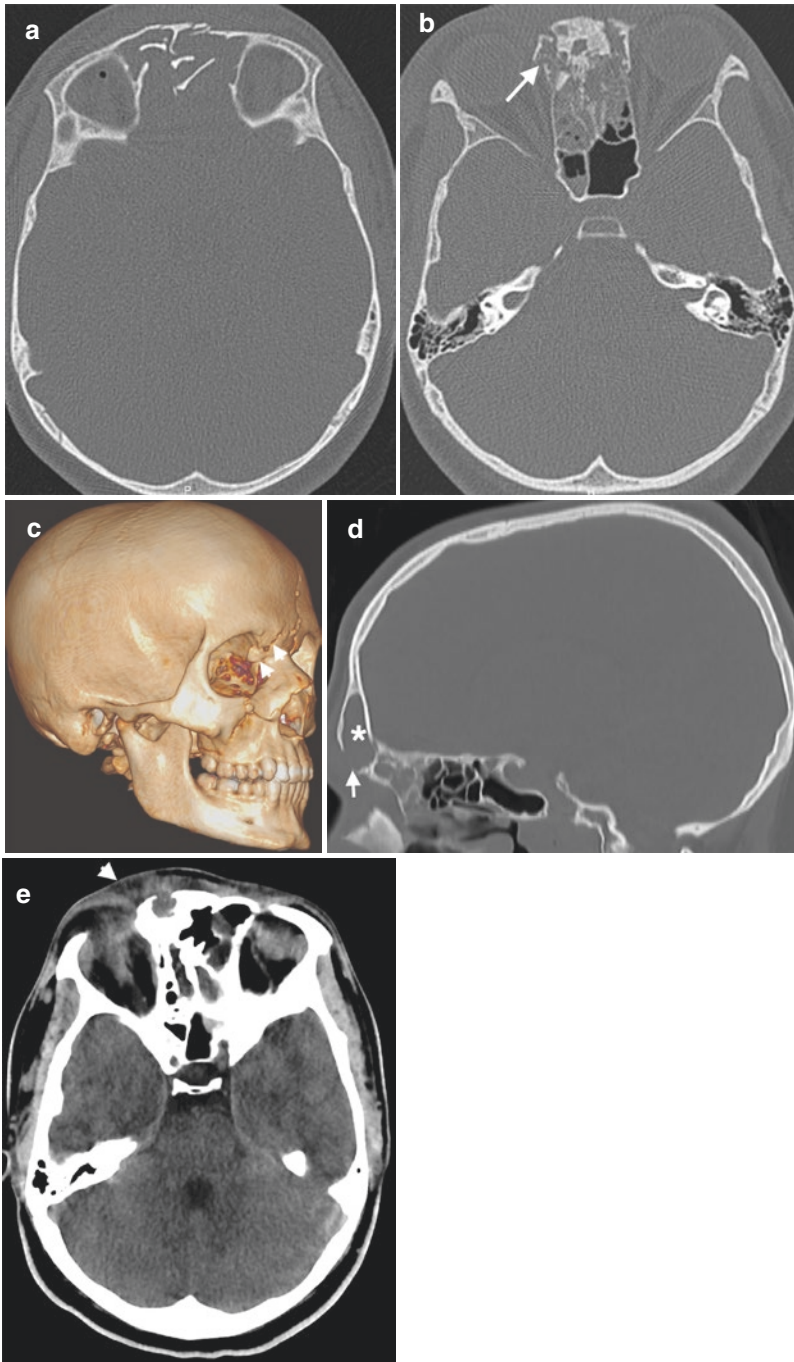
Mucopyocele formation secondary to nasofrontal duct injury. (a) Axial CT image reveals comminuted fracture of frontal sinus. (b) CT image at the level of nasofrontal recess reveals extension of fracture (arrow) along anterior and middle ethmoid air cells and nasofrontal duct region. (c) VR image demonstrates fracture (arrowheads) involving inferomedial part of the right frontal sinus. (d) Sagittal image of follow-up CT examination obtained
